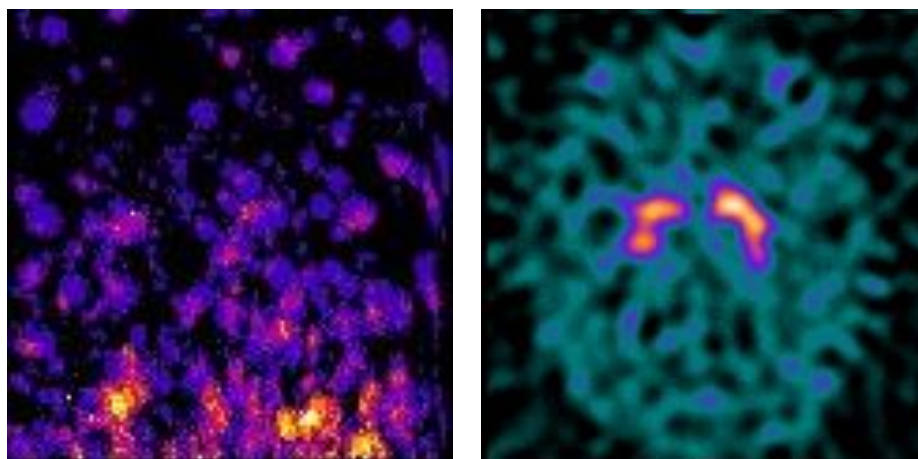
(Left) Example of planar image acquired using the HGC positioned at SCD of 8 cm on top of the head (vertex view) of patient 006, 1 hour post-administration of 185 MBq  $^{123}\text{I}$ -ioflupane, with 100 s acquisition time. (Right) Axial plane (slice 19) of the reconstructed SPECT image of the same patient acquired using SPECT-CT camera system 2.5 hours following administration with 1800 s acquisition time (30 s per projection). The image shows high striatal uptake of the dopamine transporter agent,  $^{123}\text{I}$ -ioflupane relative to cortex.
